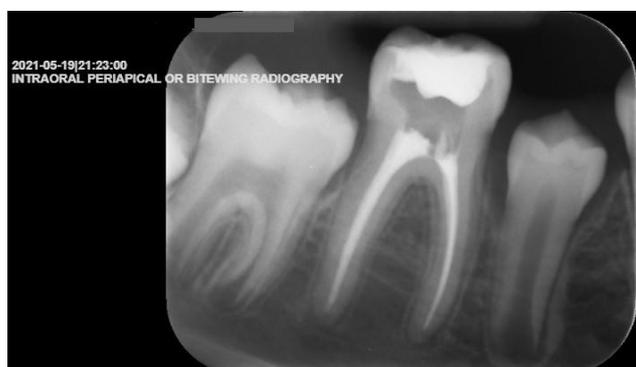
Immediate post-op radiograph of tooth 46 with no angulation
